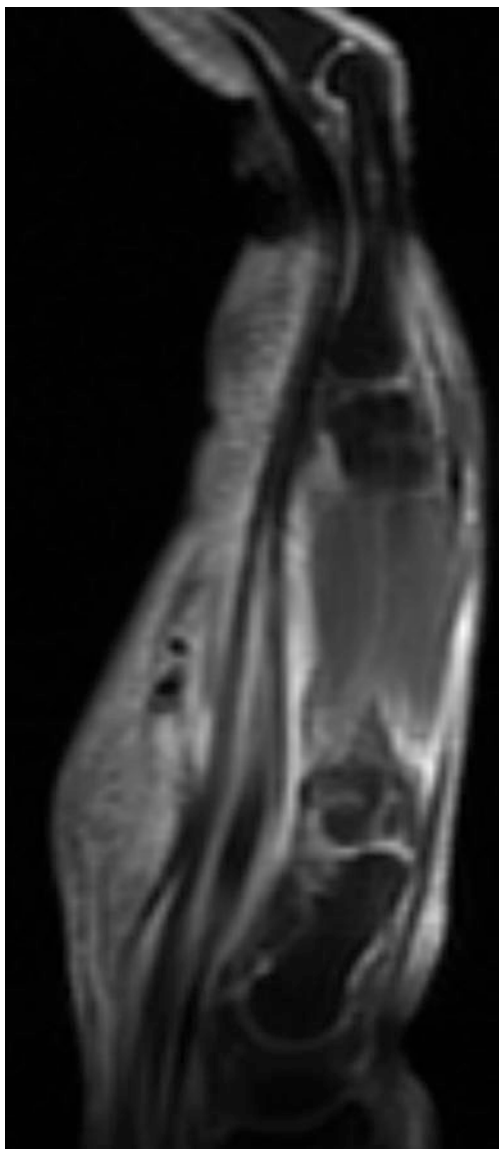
Sagittal MRI (T1 post-contrast with fat suppression) demonstrates fluid within the flexor pollicis longus tendon sheath as well as surrounding tissue edema and enhancement
